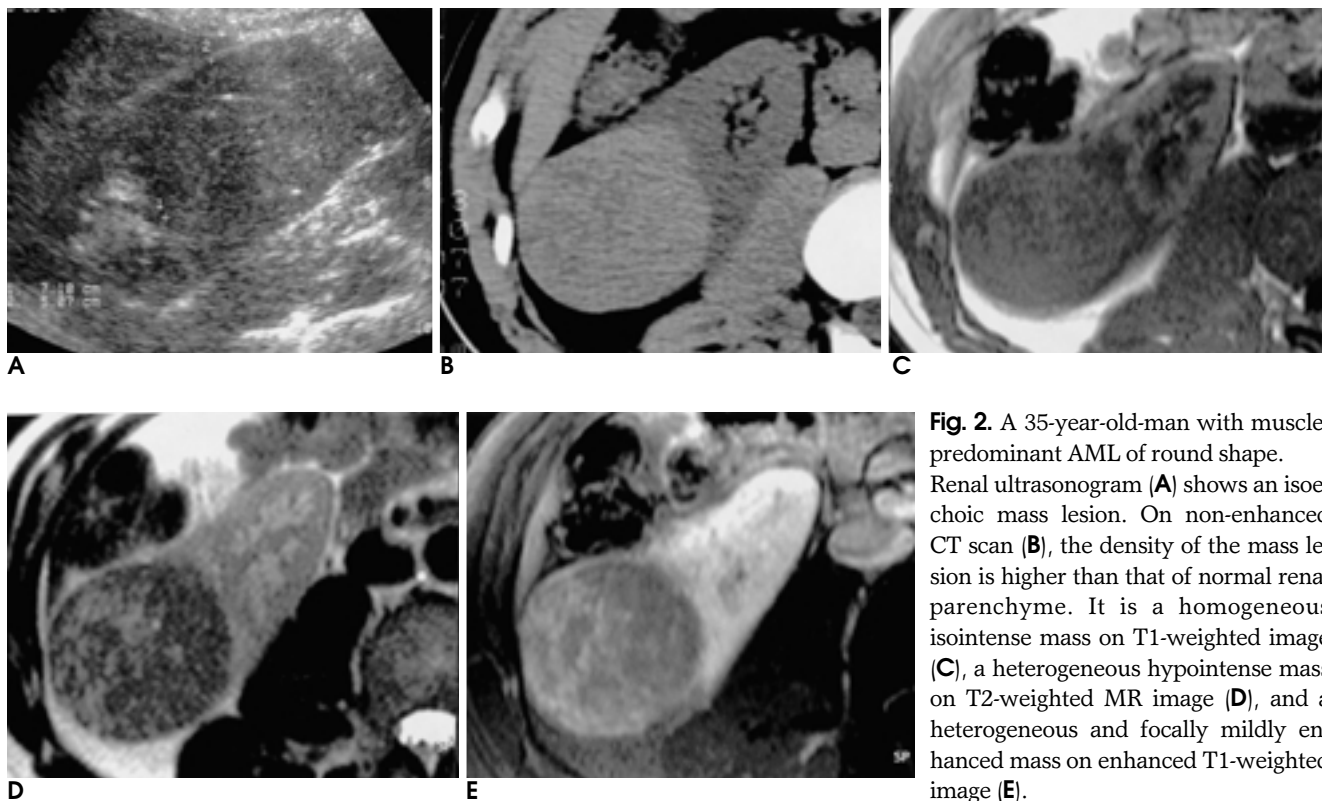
A 35-year-old-man with muscle-predominant AML of round shape. Renal ultrasonogram (A) shows an isoechoic mass lesion. On non-enhanced CT scan (B), the density of the mass lesion is higher than that of normal renal parenchyma. It is a homogeneous isointense mass on T1-weighted image (C), a heterogeneous hypointense mass on T2-weighted MR image (D), and a heterogeneous and focally mildly enhanced mass on enhanced T1-weighted image (E).
